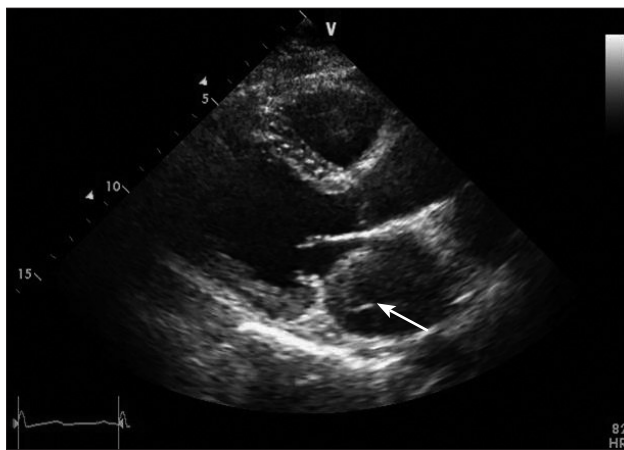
Echocardiography is a diagnostic tool of choice for left atrial dissection. Left atrium occupied by a newly developed mass (arrow) was found in parasternal long axis on postoperative day 4.
